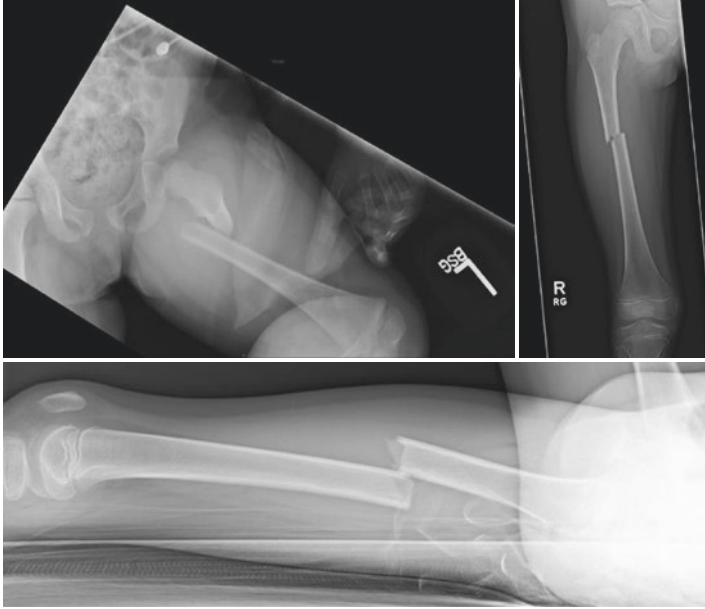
Representative radiographic images of femur fractures in skeletally immature patients
